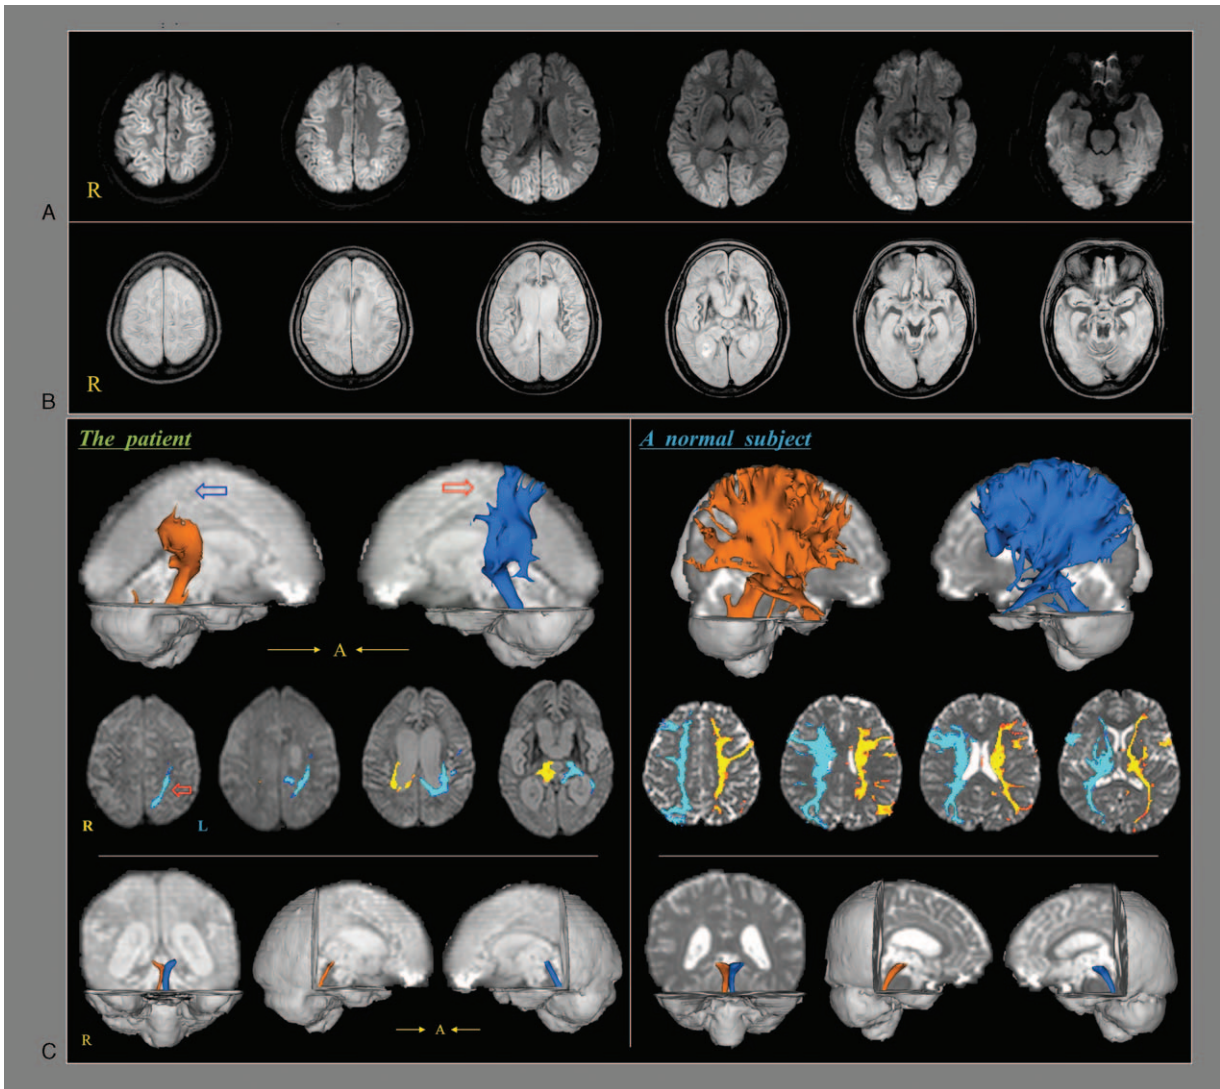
(A) Diffusion-weighted brain MR images at 4 days after onset show increased intensities in the whole cerebral cortex. (B) T2-weighted brain MR images at 3 years after onset show leukomalactic lesions in the whole cerebral cortex. (C) Results of diffusion tensor tractography for the upper connectivity of the ascending reticular activating system (ARAS). Results of diffusion tensor tractography for the upper connectivity of the ARAS showed decreased neural connectivity to each cerebral cortex in both hemispheres: the right hemisphere—no neural fibers reached the cerebral cortex (blue arrow), and the left hemisphere—some neural fibers were connected to the parietal cortex (red arrow). The right lower ARAS between the pontine reticular formation and the thalamic intralaminar nuclei was thinner compared with the left side of the patient and those of a normal subject (68-year-old female).
